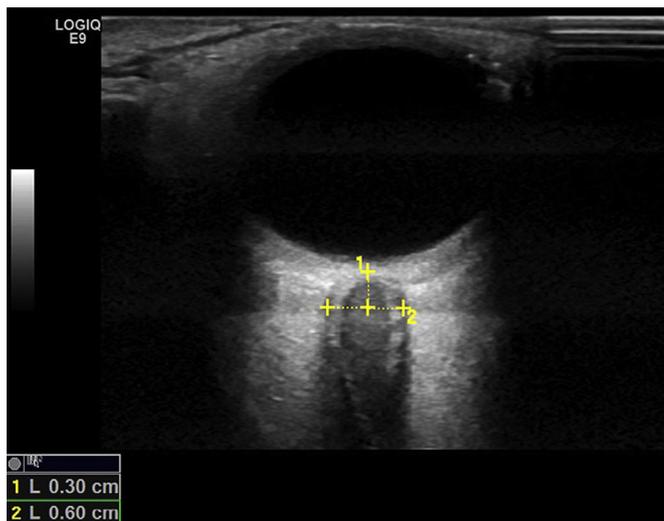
Grey-scale sonograms. ONSD measurement.
